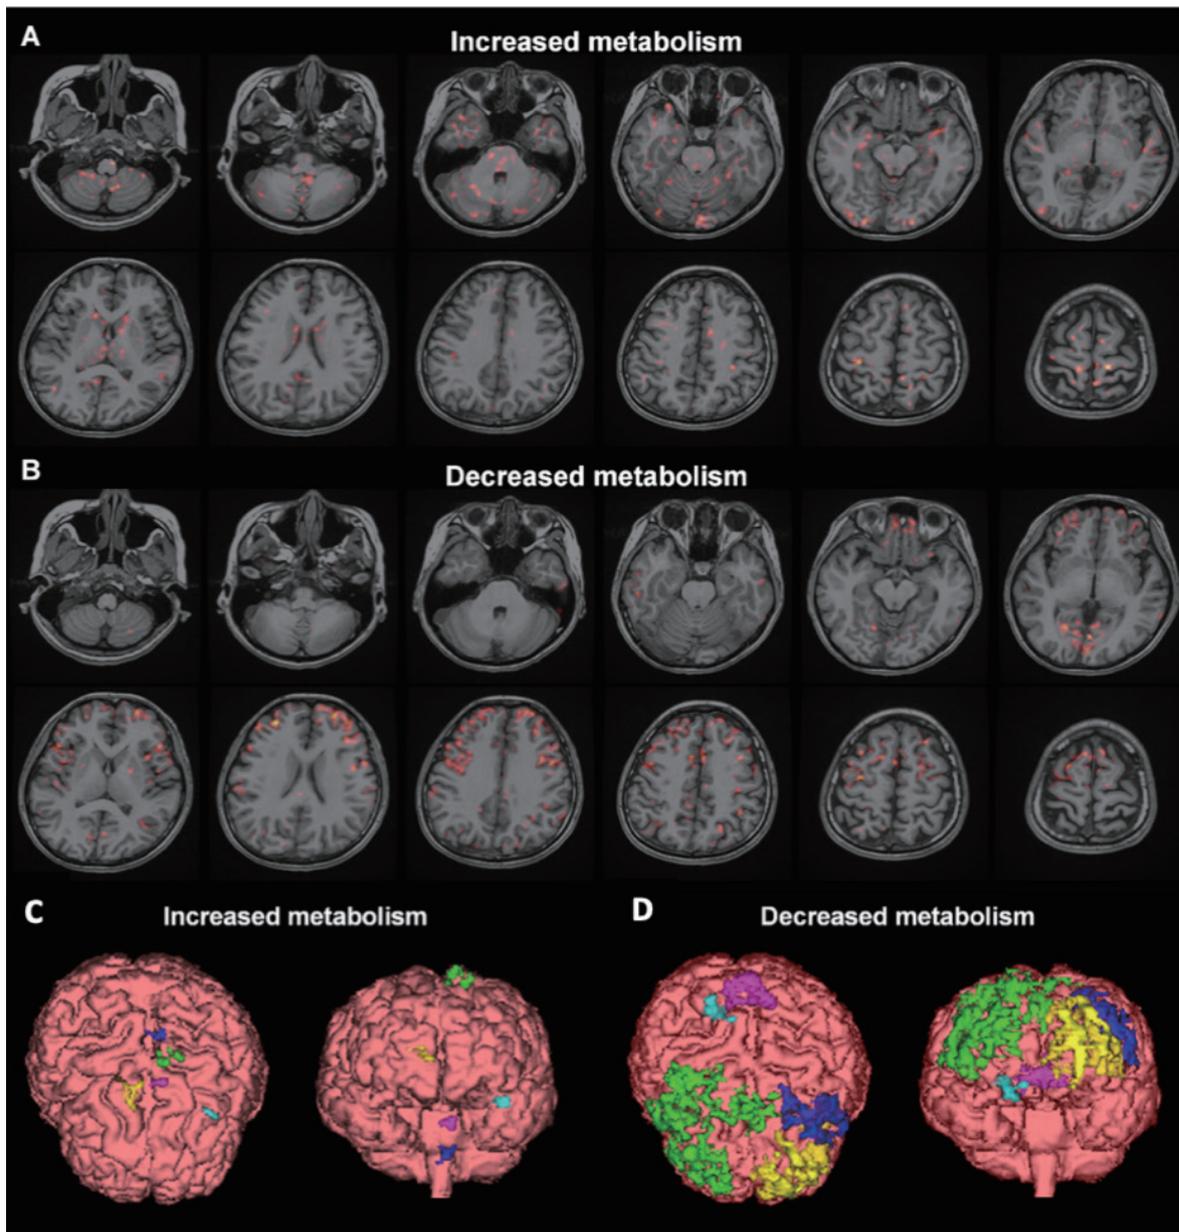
The ictal and interictal state FDG-PET comparison results superimposed on the high-resolution structural MR image. The red shadows showed increased metabolisms in the left pre-central region (A), and decreased metabolisms in the bilateral dorsal lateral frontal cortices and bilateral occipital cortices (B). The changes of metabolisms were shown on a 3D rendering of brain MR images using the following parameters: activation threshold (%) = 10, maximum activation objects = 5, and minimum activation size = 10 (C, D).
